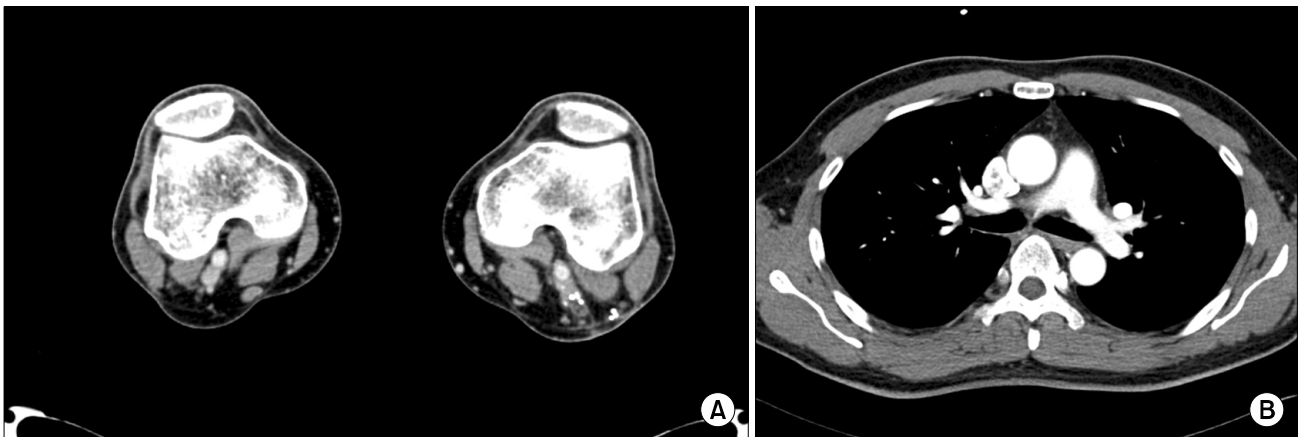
Lower extremity computed tomography (CT) angiogram findings 1 month later. (A) The aneurysm shrank with some remnants. Thrombosis of the deep veins of both the lower extremities and graft at the left popliteal fossa cannot be seen. Pulmonary thromboembolism CT scan findings 1 month later. (B) Improvement of previous pulmonary thromboembolism is noted.
